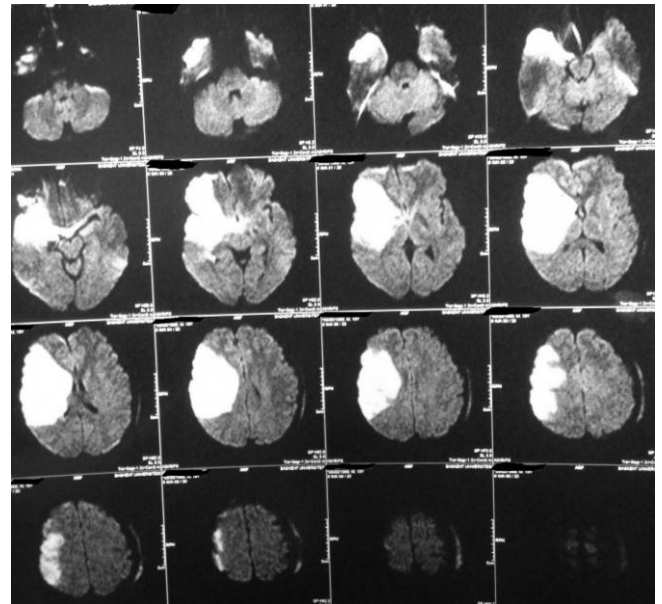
Axial DW-MRI shows a bright right MCA acute infarction.
